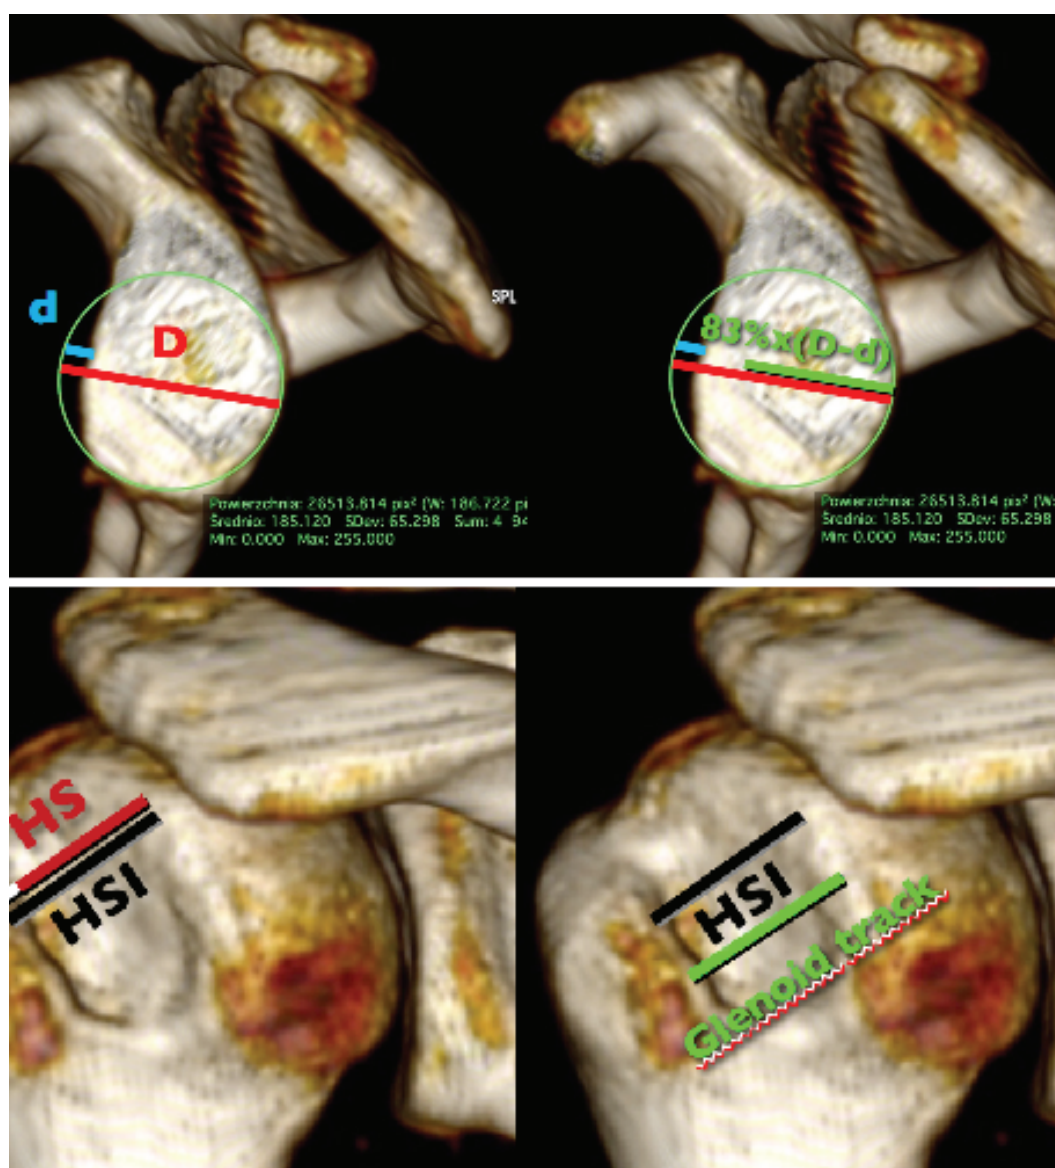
Glenoid track measurements based on 3D-CT scan. Glenoid track is calculated by deducting defect size in mm (d) from predicted normal glenoid width (D). Track size is estimated as 83% of the difference. Then HS index (HSI) is calculated by adding HS width and bone bridge (BB) between HS and tendon attachment. HS is off-track if HSI is larger than glenoid track.
